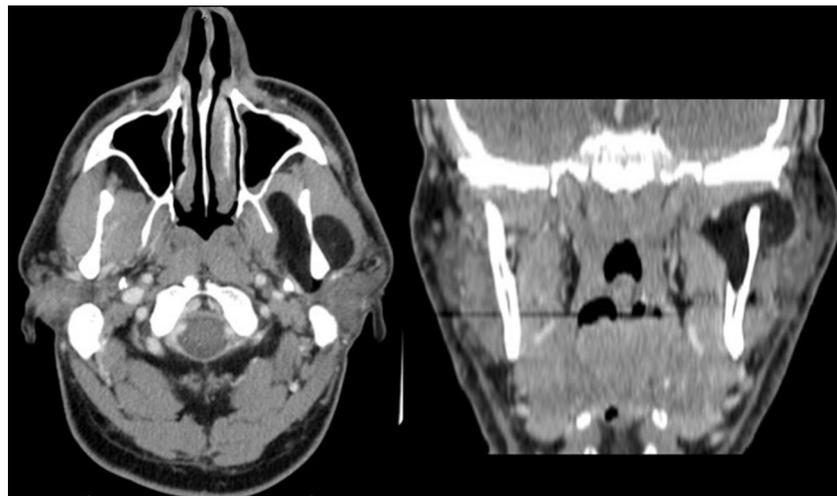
Pre operative CT scan: revealed a well-circumscribed mass with adipose tissue signal density measuring 42 × 27 mm in the left masticator space.
